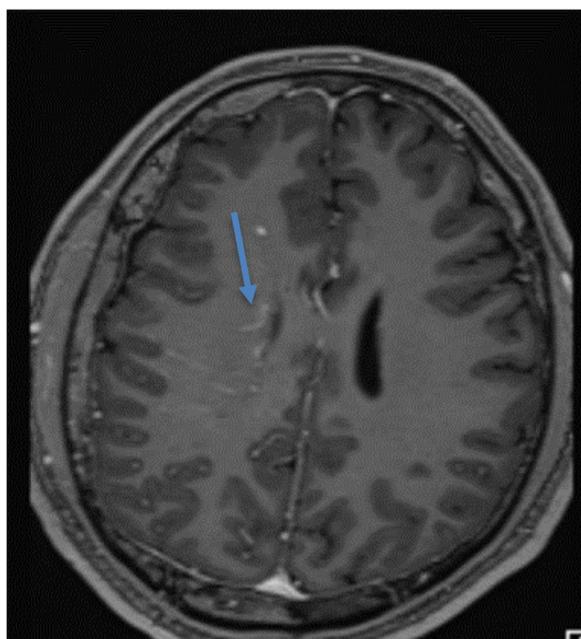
Brain magnetic resonance image, axial T1-weighted with contrast sequences shows atrophy of the right parietal lobe with leptomeningeal enhancement (arrow) suggesting Sturge-Weber syndrome
